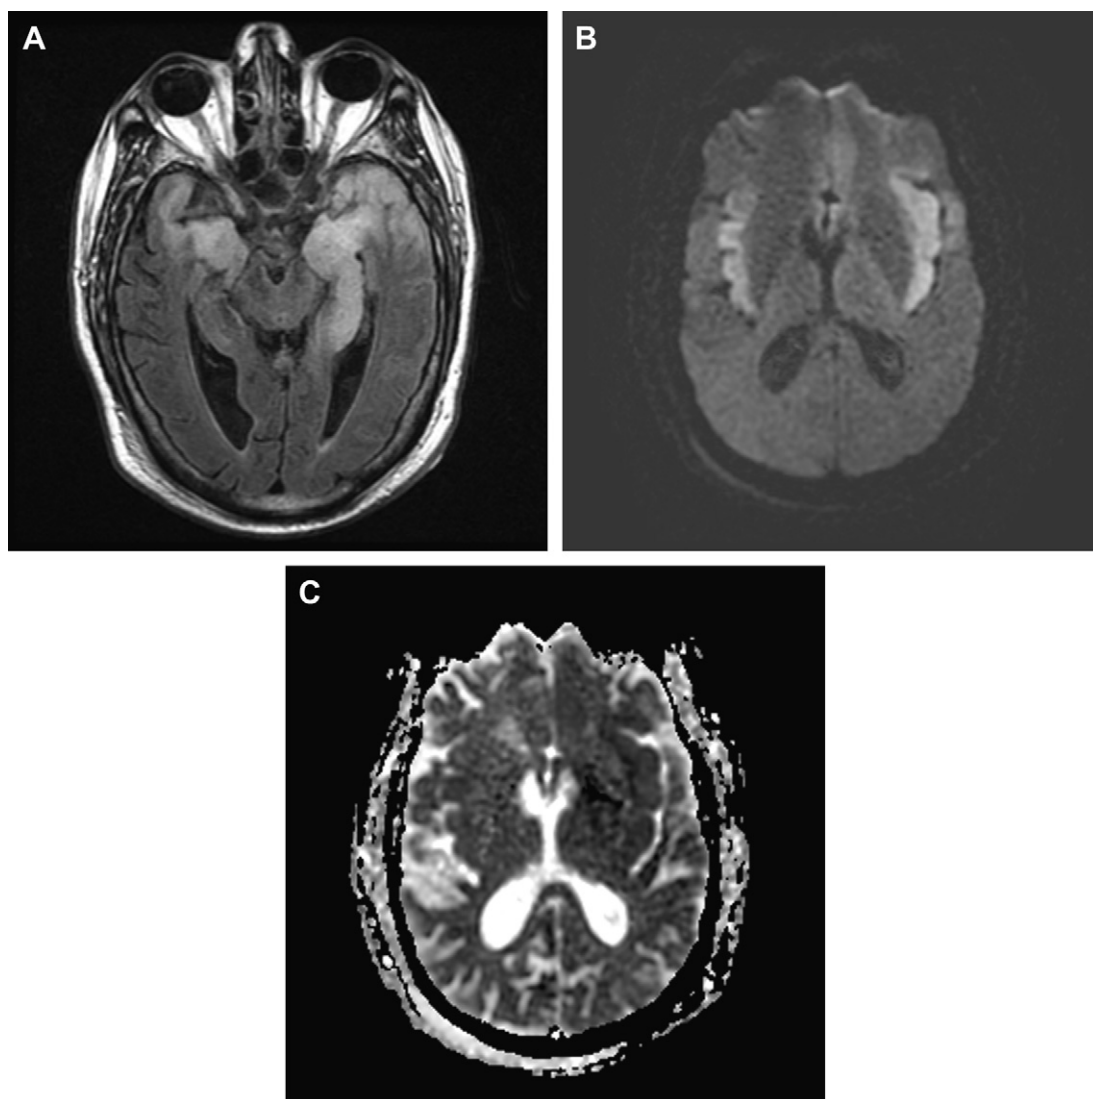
Herpes simplex encephalitis. Axial FLAIR (A) image demonstrates bilateral, asymmetric temporal lobe signal abnormalities. Diffusion-weighted image (B) and the corresponding ADC map (C) demonstrate areas of restricted diffusion. Postcontrast T1 images (not shown) demonstrated minimal associated enhancement.
